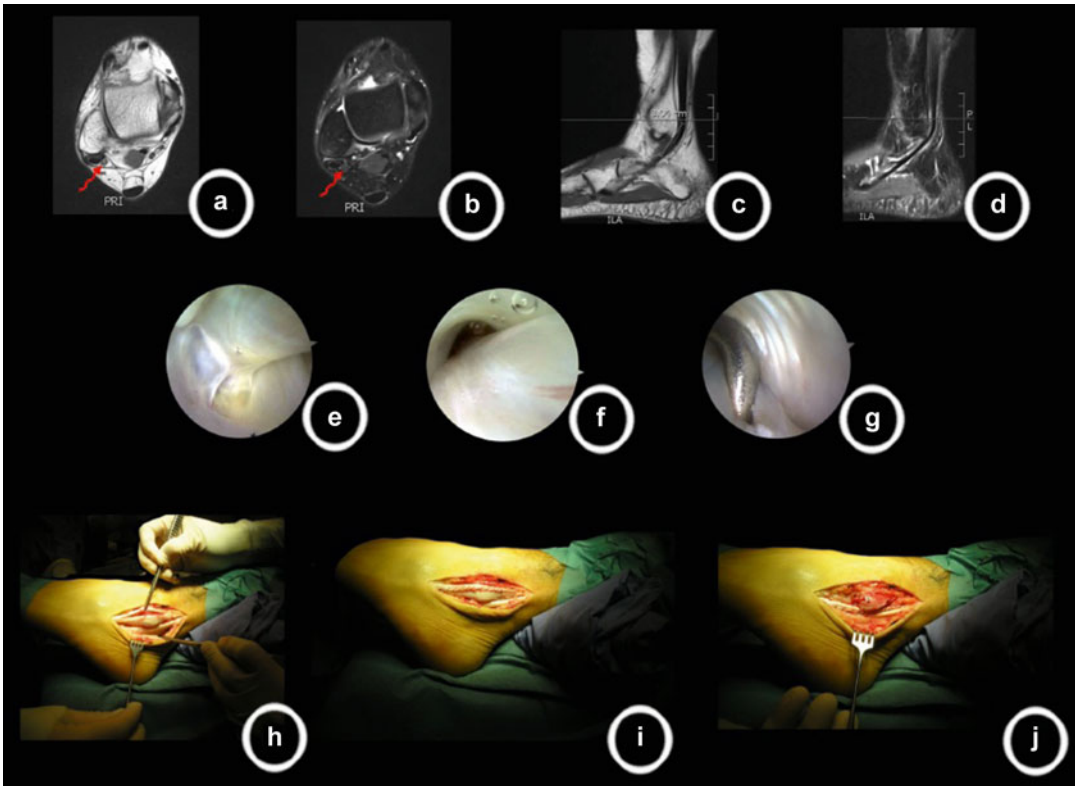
A 25-year-old female patient with a symptomatic peroneus brevis tendon tear at the left side. (a) Axial T1-weighted magnetic resonance image (MRI) indicating a C-shaped peroneus brevis tendon and signaling change within the tendon sheath, suggestive for a tear; (b) axial T2-weighted MRI indicating a C-shaped peroneus brevis tendon, suggestive for a tear; (c) sagittal T1-weighted MRI indicating the location of the tear; (d) sagittal T2-weighted MRI indicating the location of the tear; (e) arthroscopic image from the most proximal proportion of the peroneal tendons; (f) arthroscopic image of the peroneus brevis tendon with mild tenosynovitis, indicating
